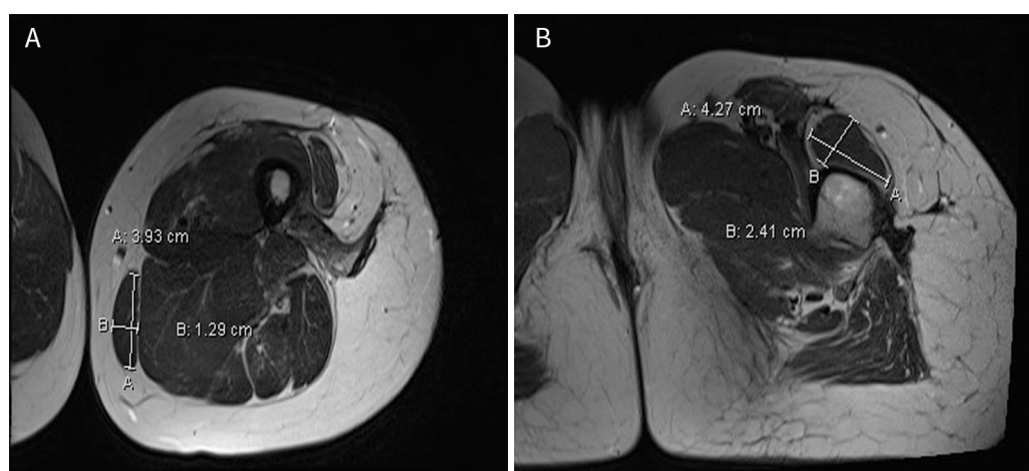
MRI showing gracilis muscle hypertrophy post free functional gracilis to left leg: (A) pre-operative MRI; and (B) 36-month post-operative MRI. MRI: magnetic resonance imaging
